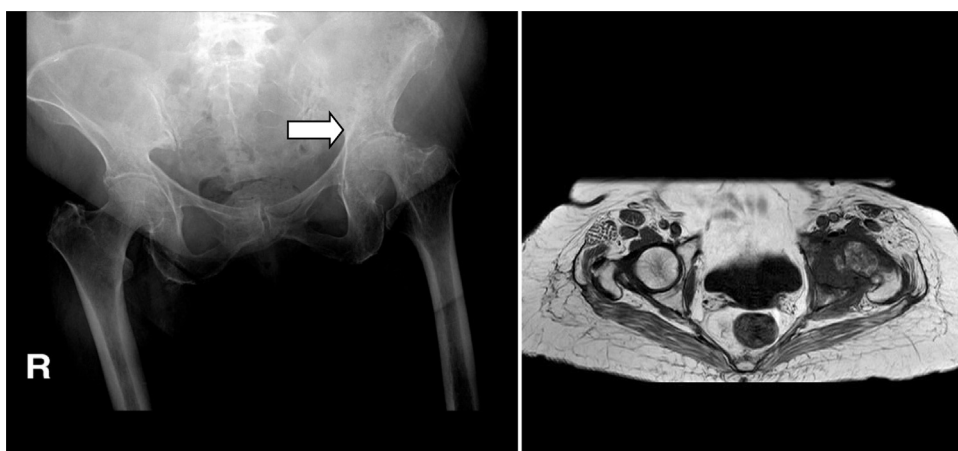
Preoperative radiograph showing cephalic bone necrosis and magnetic resonance image demonstrating avascular necrosis and acetabular bone changes.
